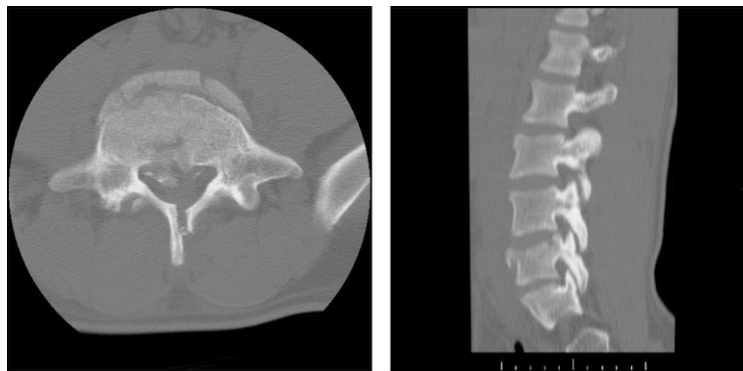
Axial and sagittal CT reconstructions of an AO-A3 burst fracture, showing failure of the anterior and posterior aspects of the superior end plate of L5.
